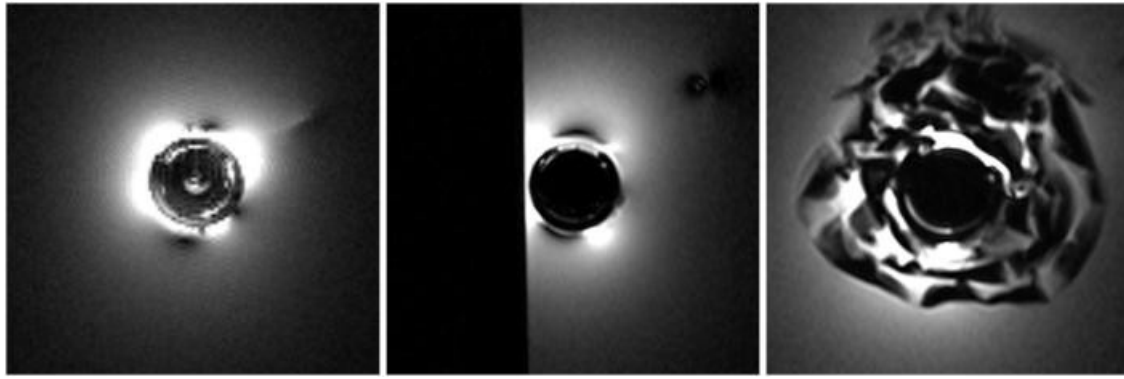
Axial MRI of duodenoscope tip coil showing alternative signal loading cases (SLC): Case 1 (left) idealised with coil surrounded by liquid; Case 2 (centre) plastic block placed adjacent to coil and; Case 3 (right) coil wrapped in air-filled plastic packing material.
